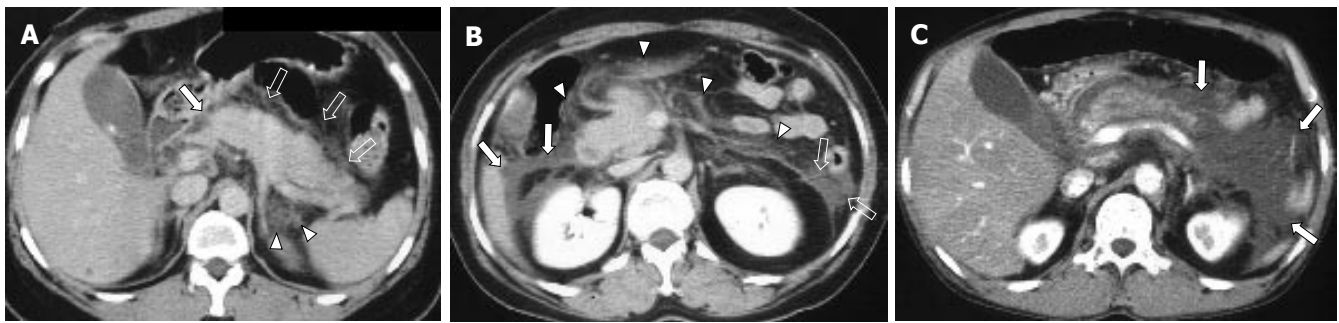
Peripancreatic infiltration scores (1-3). A: Score 1 (Irregular peripancreatic infiltration without fluid collection). CT showing irregular strands of peripancreatic fat infiltrations in the compartment of RP (arrow), LP (open arrows), and LSR (arrowhead); B: Score 2 (Peripancreatic fluid collection with no or equivocal degree of mass effect). CT showing multiple fluid collections without mass effect in the compartment of RSR (arrows) and LSR (open arrows). Score 1 infiltrations in the compartment of RP and LP (arrowheads) are also seen; C: Score 3 (Peripancreatic fluid collection with definite mass effect to adjacent organs). CT showing score 3 fluid collection in the LP and LSR compartments (arrows) displacing or compressing adjacent bowels.
